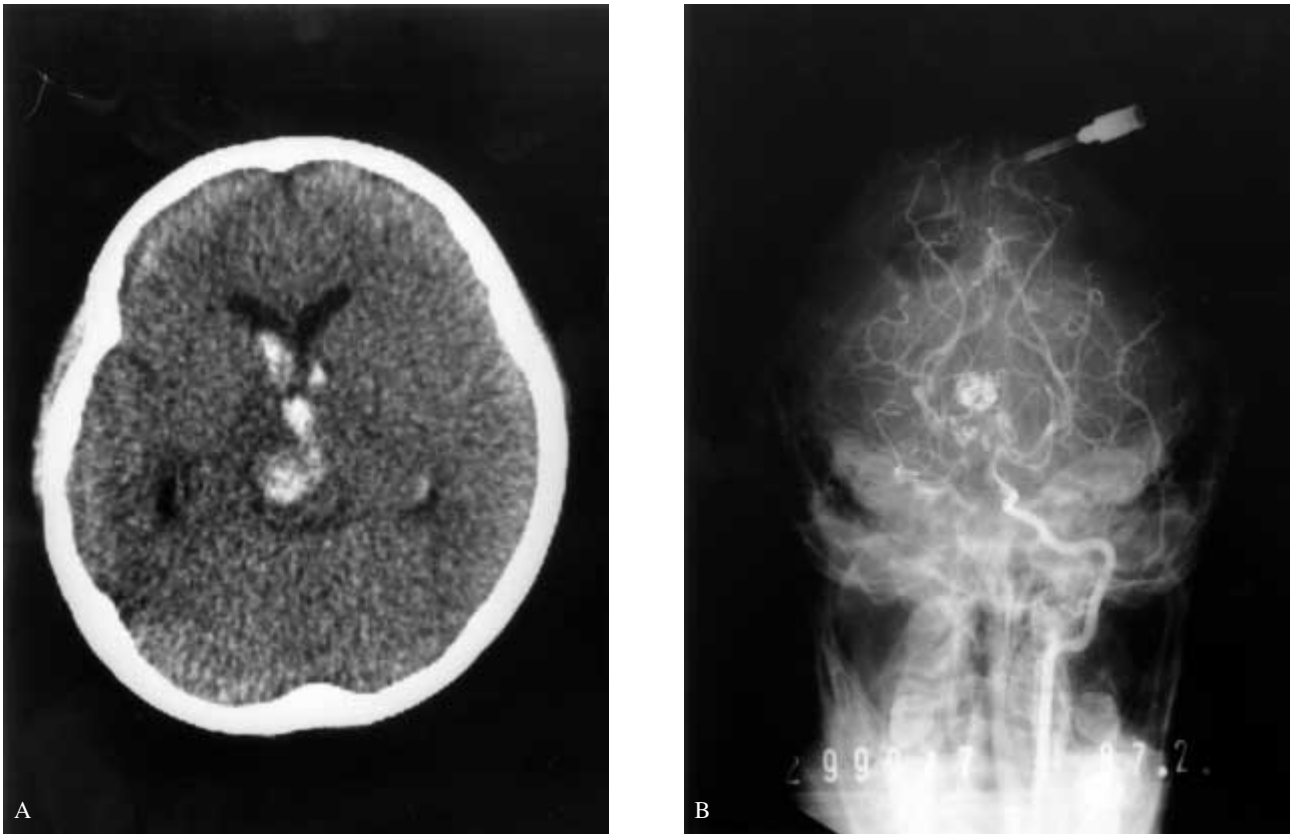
(A) Computed tomography of the brain shows a right thalamic hemorrhage and intraventricular rupture. (B) Left vertebral angiography reveals arteriovenous malformation (AVM) at the right posterior thalamus to the midbrain with feeders from the posterior thalamoperforate artery.
